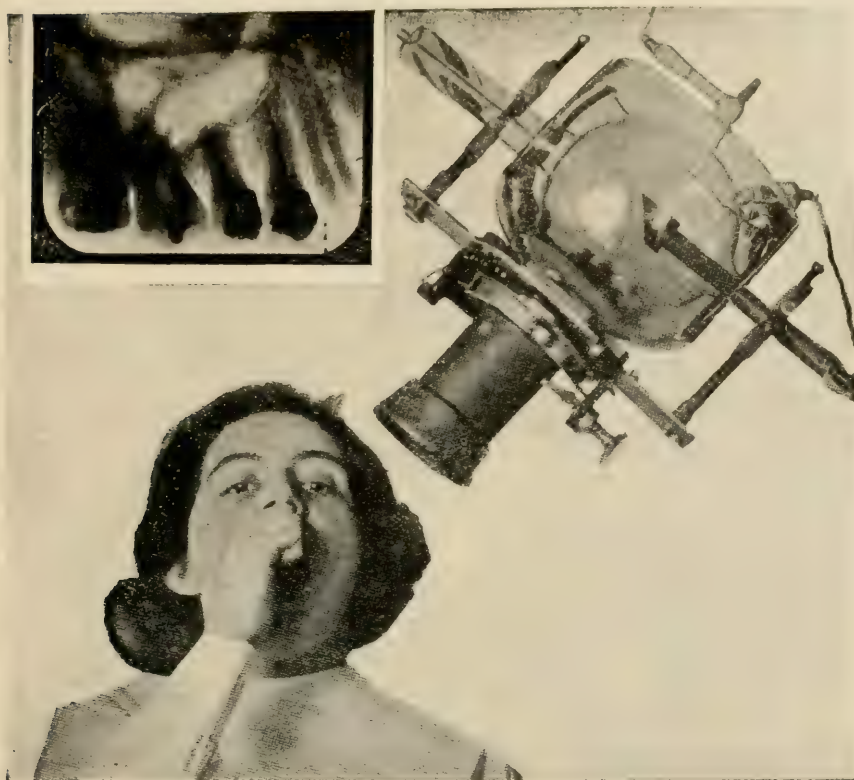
Incorrect pose for radiographing upper bicusps and molars, and a radiograph made from the pose.
